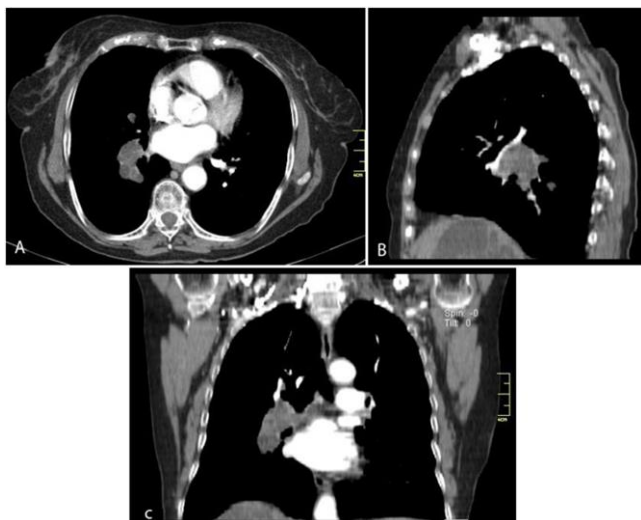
Axial (A) sagittal (B) and coronal (C) multiplanar reformatted CT of the chest images showing a multiple cystic lesion within the right main and lower lobe pulmonary artery
